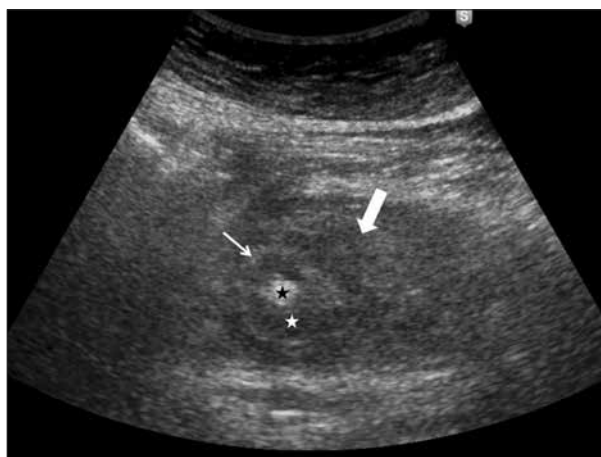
Transabdominal ultrasonography – axial ultrasound scan in the right hypochondrium: thickened and homogenous hypoechoic D2 duodenal wall (white star, thin arrow), with the hypoechoic periduodenal mass (thick arrow), represents intramural and periduodenal hematoma (black star indicates narrowed duodenal lumen)
